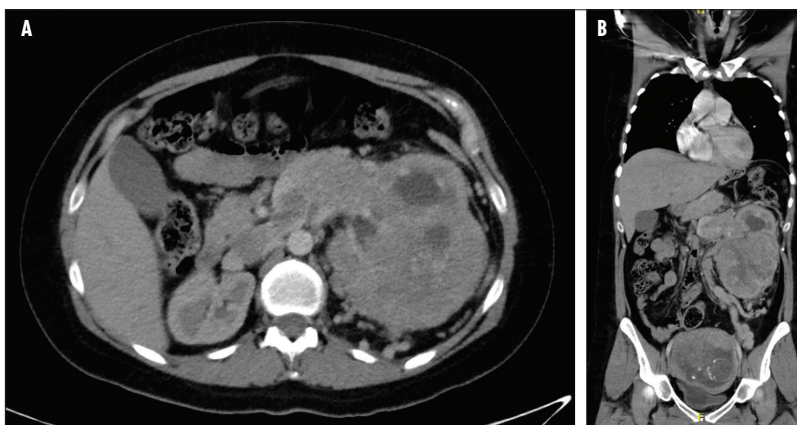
Representative computed tomography (CT) axial (A) and coronal (B) images of a large left renal mass with thrombus extending throughout the left renal vein into the inferior vena cava in a patient at 17+4 weeks gestation.
